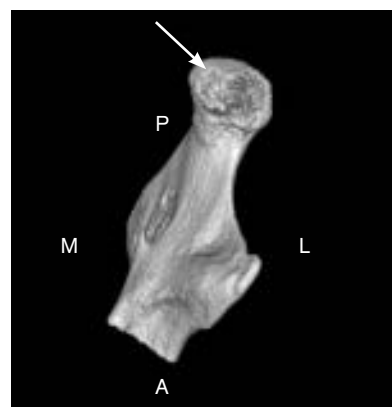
Cone beam computed tomography image: Arrow shows that the cranial cortical surface of the condyle is not perforated but has a rough appearance. A = anterior; P = posterior; L = lateral; M = medial.
